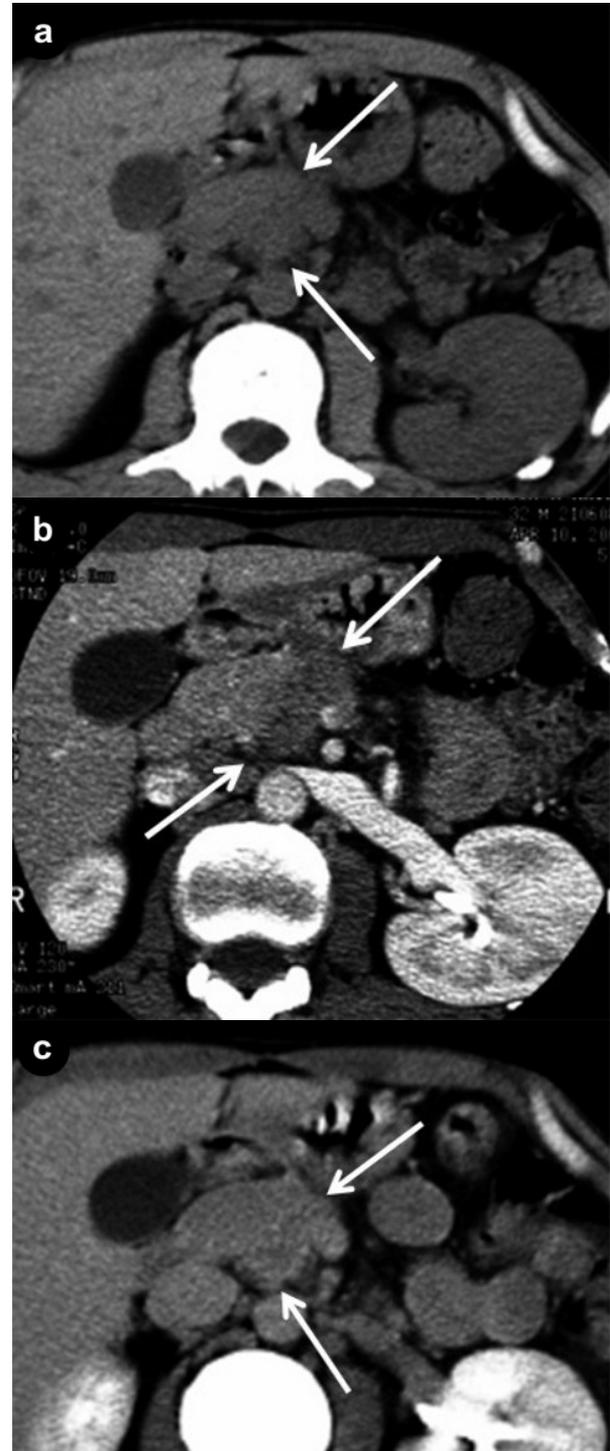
Abdominal computed tomography showing a low density mass 28 mm in diameter in the pancreatic head (a.), with little and weak enhancement in the early (b.) and delayed phases (c.), respectively (arrows).
